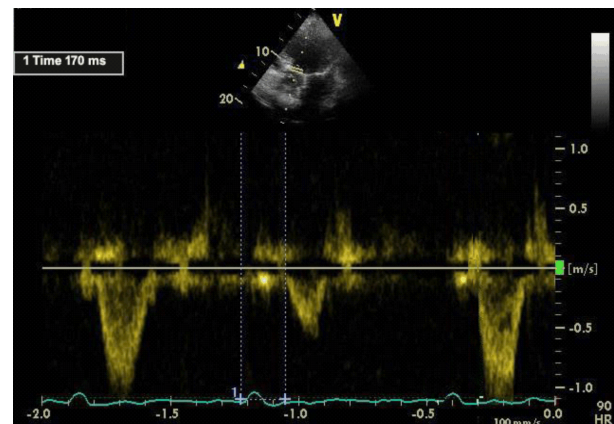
Transthoracic echocardiography in apical 5-chamber view. Pulsed wave Doppler acquisition. Measurements of aortic pre-ejectional period (PEP) in a dilated cardiomyopathy patient. PEP: 171 ms.
